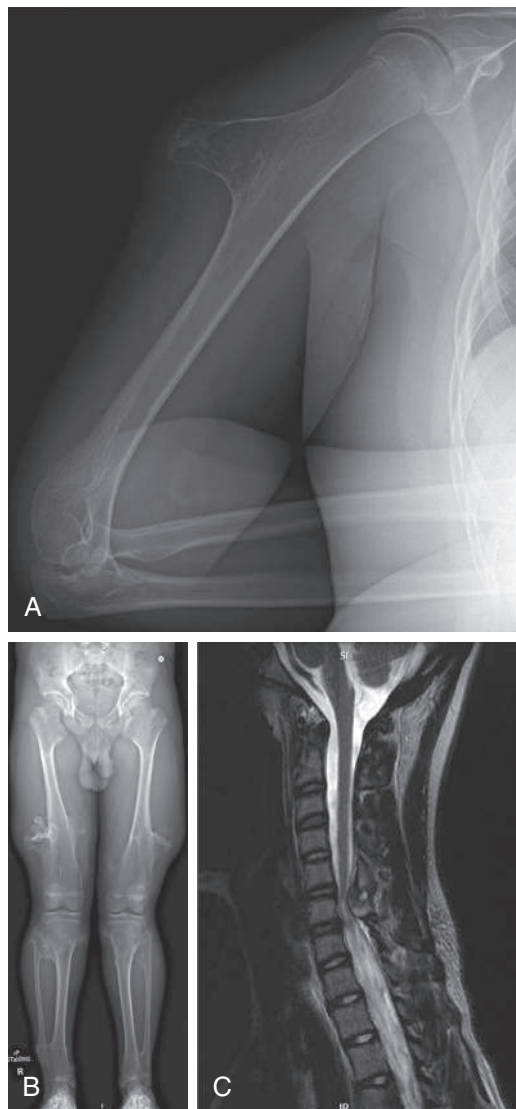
A, Lateral radiograph of the right humerus showing isolated osteochondroma. Bone lesion is in continuity with the medullary canal and points away from the growth plate. B, Hip-to-ankle radiograph in a child with multiple hereditary exostoses (MHE) showing many osteochondromas about the knees and ankles. C, Sagittal T2 weighted MR image of the cervical spine in a 15-yr-old female with MHE who underwent routine cervical screening MRI, which detected asymptomatic spinal stenosis caused by C6 osteochondroma. She underwent urgent decompression.
